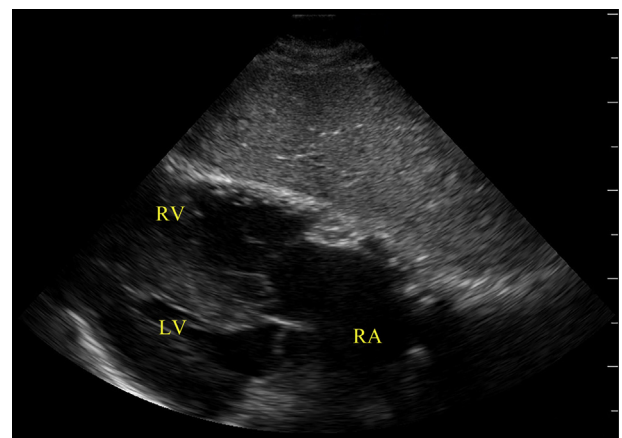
Subcostal view on transthoracic POCUS demonstrates echodensity is no longer visible. *LV*, Left ventricle; *RA*, right atrium; *RV*, right ventricle.
